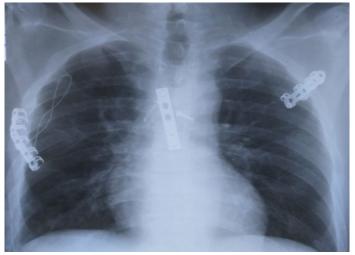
Chest radiography (Neuro-Rehabilitation Clinic Division of the THEBA, casuistry)
